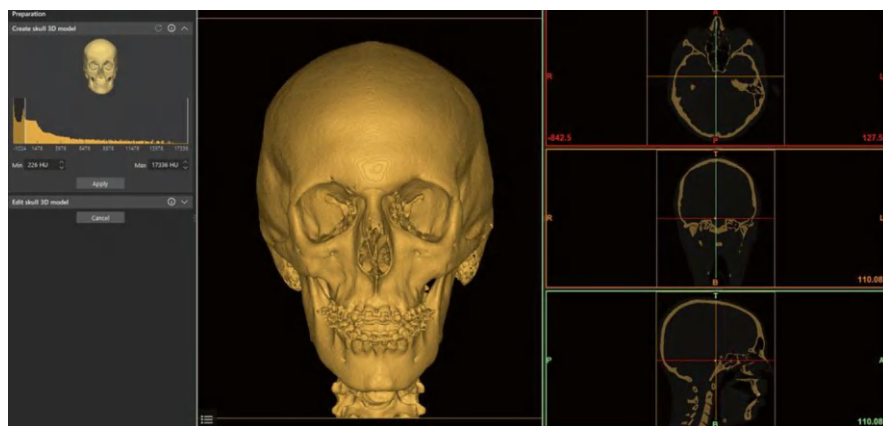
Combining the CT/CBCT with the intraoral scans or dental casts using Mimics Enlight CMF™. (This image has been reproduced with the kind permission of Mimics, Materialise, Leuven, Belgium)
